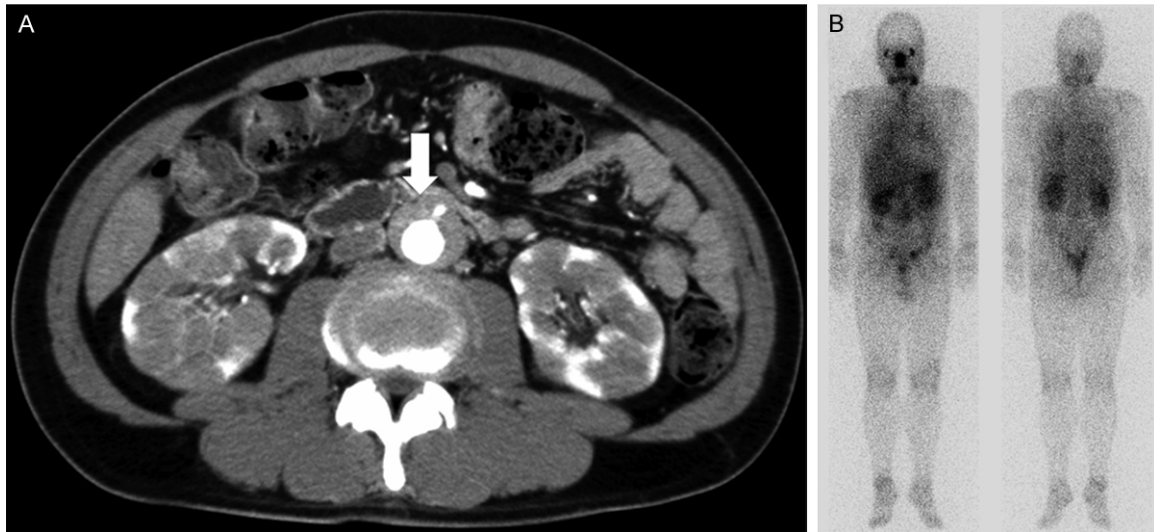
Detection of (A) renal lesions and periaortitis by computed tomography (CT) and (B) gallium-67 (Ga) accumulation on the submandibular gland, bilateral renal, and around the aorta by Ga scintigraphy.
